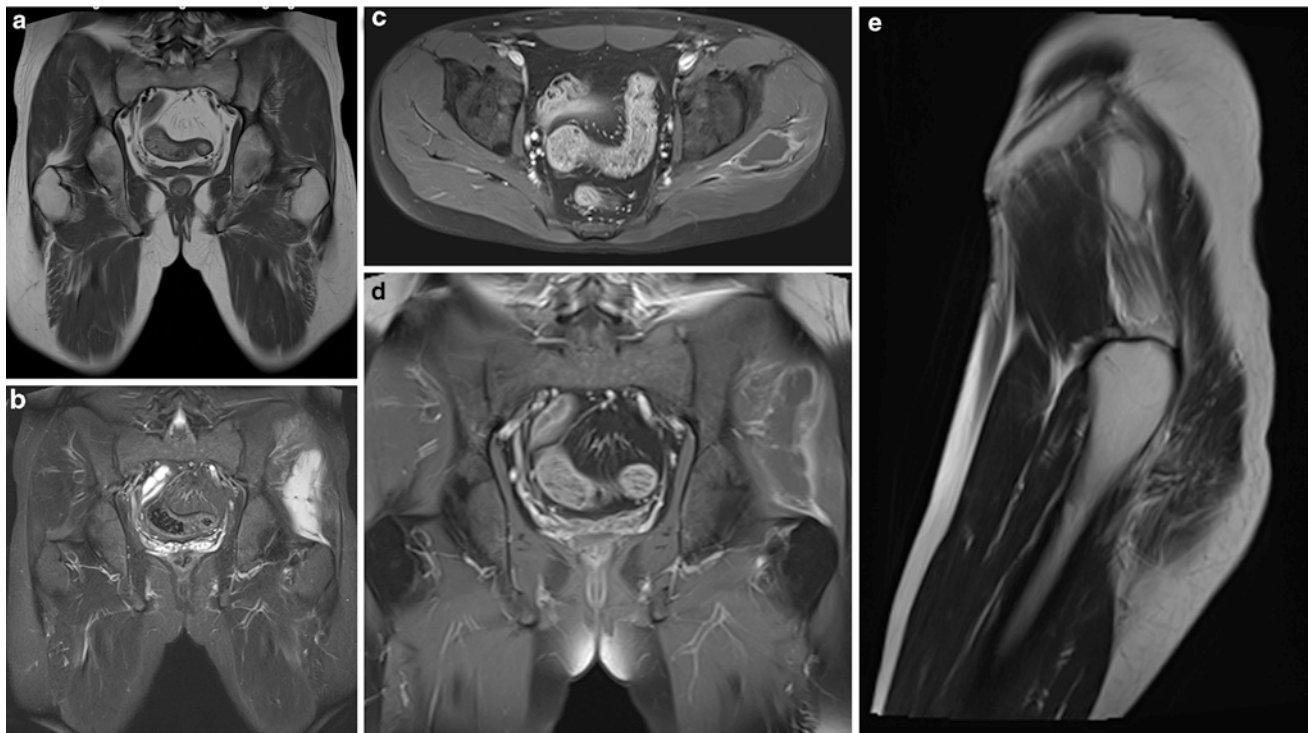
A 23-year-old woman with muscle abscess formation in the left gluteal muscles. MRI images (coronal T1-weighted (a) and STIR images (b), axial (c) and coronal (d) fat-saturated contrast-enhanced T1-weighted images and sagittal T2-weighted (e) image) show a
